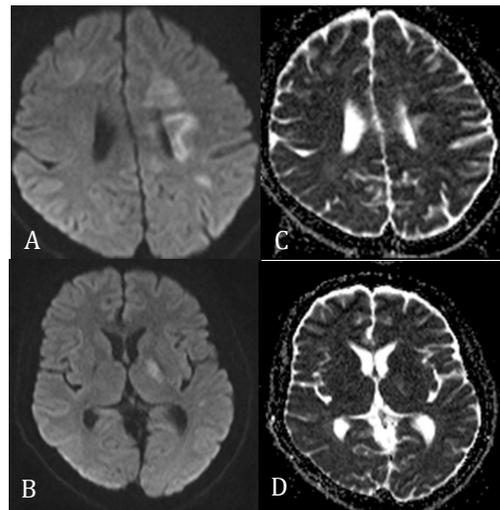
(A, B, C & D): MRI brain axial sections - DWI and ADC images demonstrate subtle areas of restricted diffusion in left corona radiata and thalamus.
